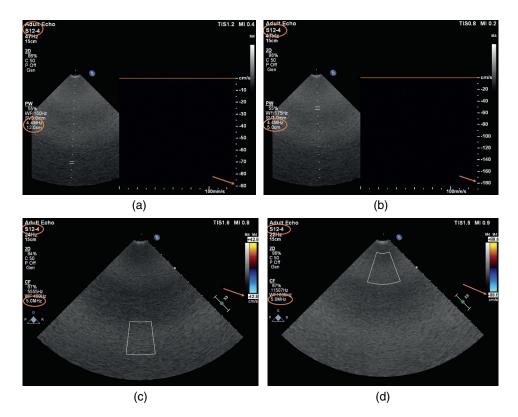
Increasing depth of a PW gate decreases the Nyquist limit, resulting in lower aliasing velocities, and decreased depth allows for higher aliasing velocities. (a) At a Doppler frequency of 4.4 MHz and gate depth of 12 cm (circle) the aliasing velocity is 90 cm/s (arrow). (b) At a Doppler frequency of 4.4 MHz and gate depth of 5 cm (circle) the aliasing velocity is 180 cm/s (arrow). (c) At a Doppler frequency of 5 MHz (circle) and a deep color box the aliasing velocity is 42.8 cm/s (arrow). (d) At a Doppler frequency of 5 MHz (circle) and a shallow color box the aliasing velocity is 88.6 cm/s (arrow).
